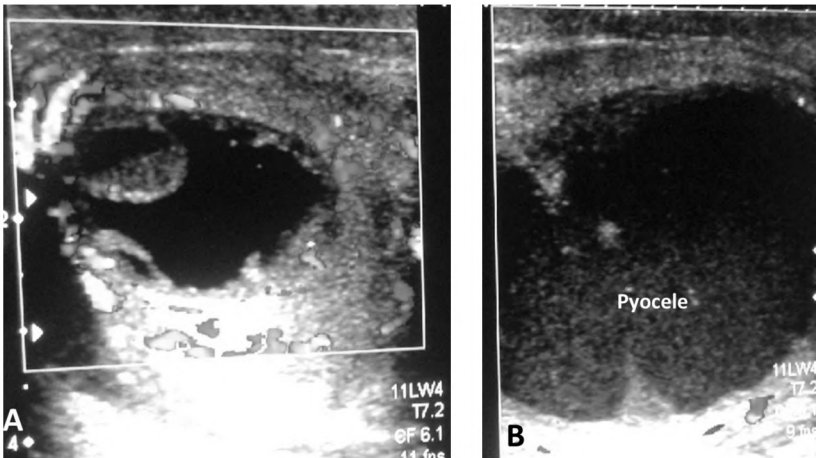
Pyocele in a neonate. (A) Color Doppler image demonstrating increase vascularity around the pyocele. (B) Sonography image shows large amount of turbid fluid (pyocele).
